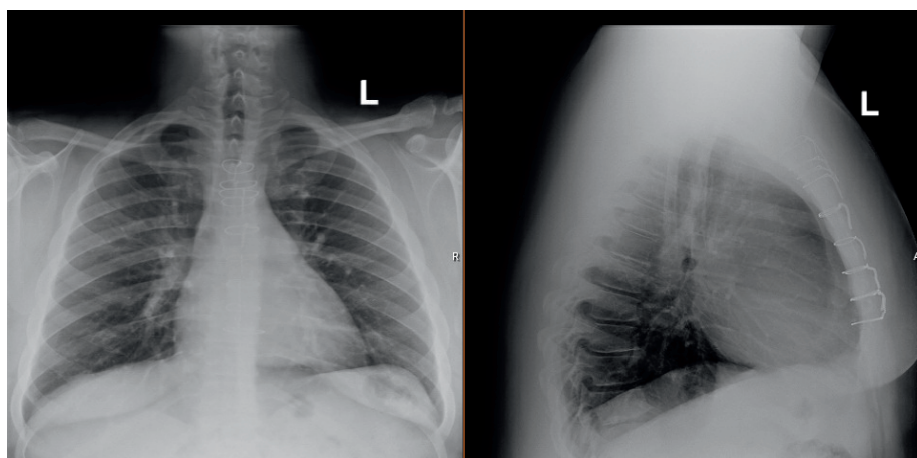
Chest radiograph demonstrating prominent descending right pulmonary artery, right ventricular enlargement with loss of retrosternal space.
